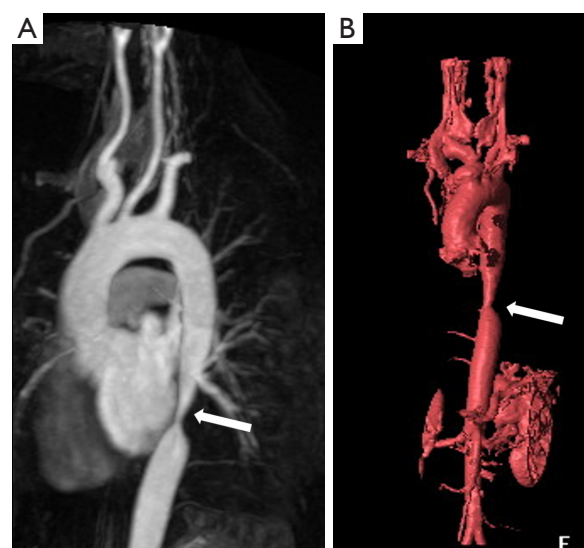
A 27-year-old woman with Takayasu arteritis. (A) Magnetic resonance angiography showing severe narrowing of the descending thoracic aorta (white arrow). (B) 3-dimensional volume-rendered magnetic resonance image showing severe narrowing of the descending thoracic aorta (white arrow).
